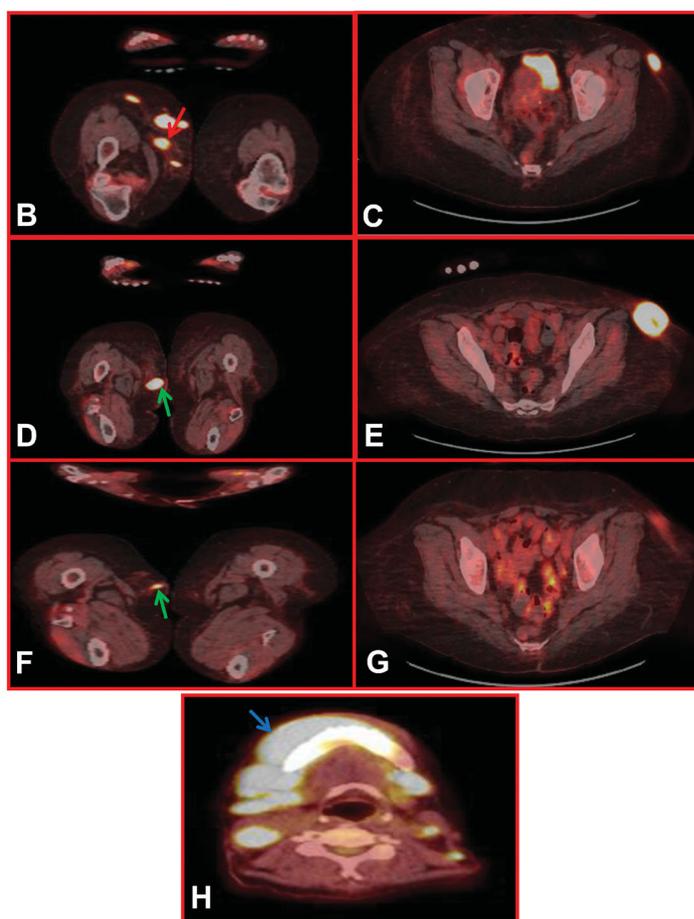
(A) Diagnostic Laboratory Studies. (B) PET-CT images of right inner thigh soft tissue tumors prior to initiation of XmAb[®]13676. (C) PET-CT images of left anterolateral thigh soft tissue tumor prior to initiation of XmAb[®]13676. (D) PET-CT images of right inner thigh soft tissue tumors after two cycles of XmAb[®]13676. (E) PET-CT images of left anterolateral thigh soft tissue tumor after two cycles of XmAb[®]13676. (F) PET-CT images of right inner thigh soft tissue tumors after four cycles of XmAb[®]13676. (G) PET-CT images of left anterolateral thigh soft tissue tumor after four cycles of XmAb[®]13676. (H) PET-CT images of mandibular mass developing after 7.5 cycles of XmAb[®]13676.
